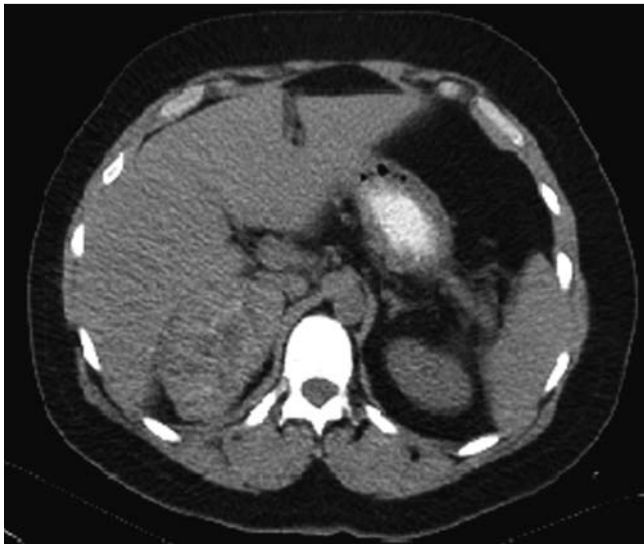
Patient 2: computed tomography (CT) scan showing right adrenal gland mass.
